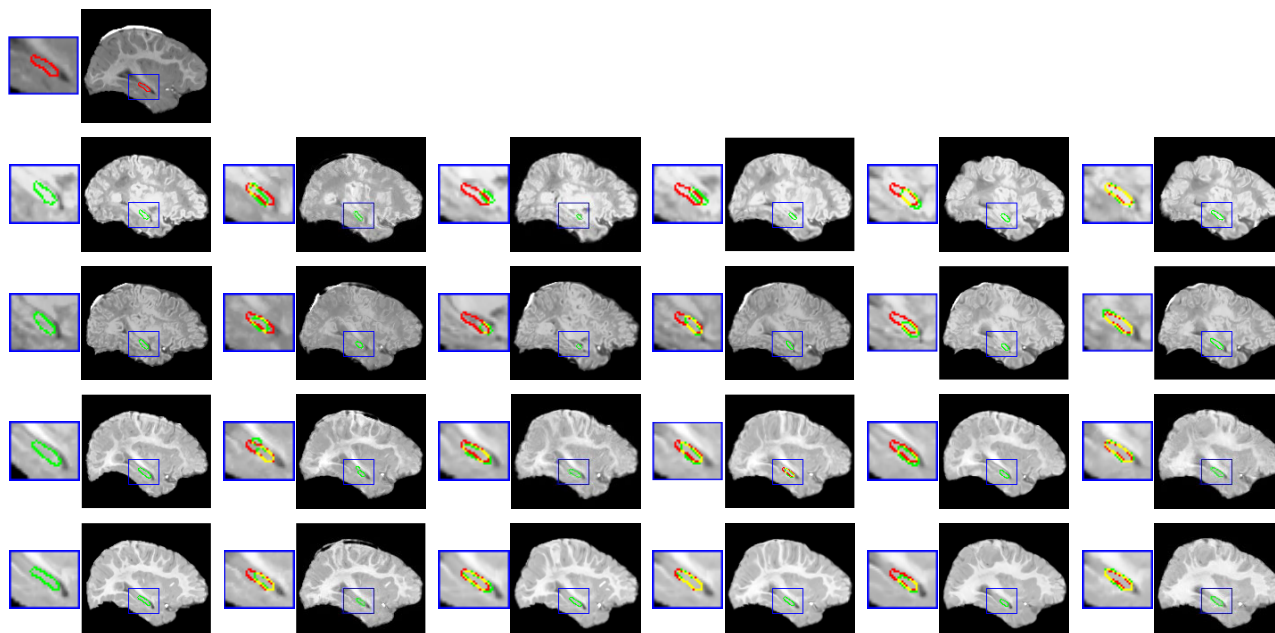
Visualization of the intersubject registration of T1-weighted MR images. The sagittal slices are in the same order as in Fig. 5. Our proposed method still realizes the largest hippocampus overlaps (shown in the last column).
